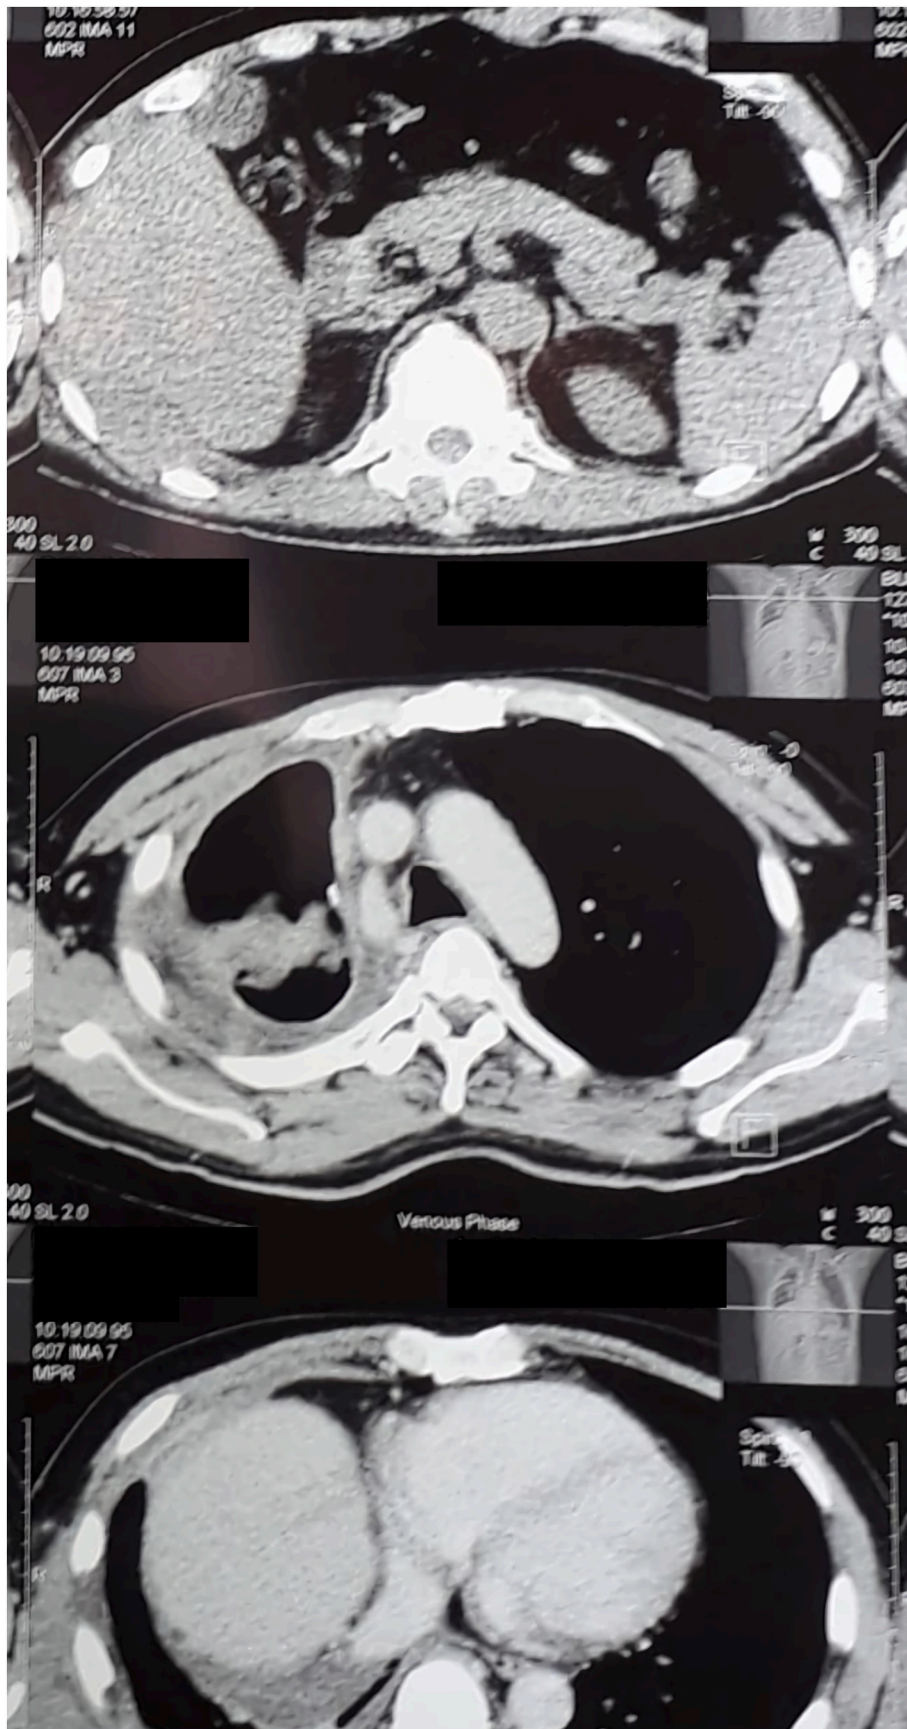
Right lung mass in CT-Scan thorax with contrast.
